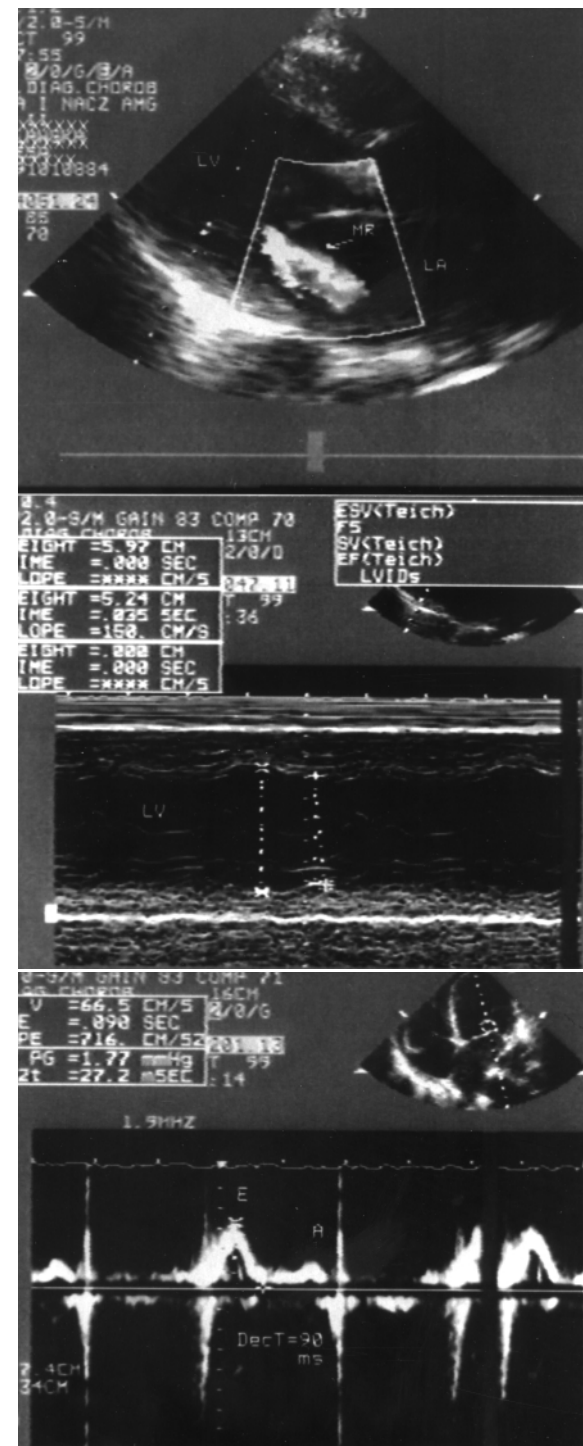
Case 1: Echocardiographic examination before treatment. A, Parasternal long axis view, dilated left ventricle (LV) and left atrium (LA). Jet of mitral regurgitation (arrow) detected in colour Doppler technique. B, M-mode: Abnormal diastolic and systolic diameter of the left ventricle with low ejection fraction (EF, 35%). C, CW Doppler curve: restrictive type of the mitral inflow pattern with short deceleration of E wave and E/A >2.
